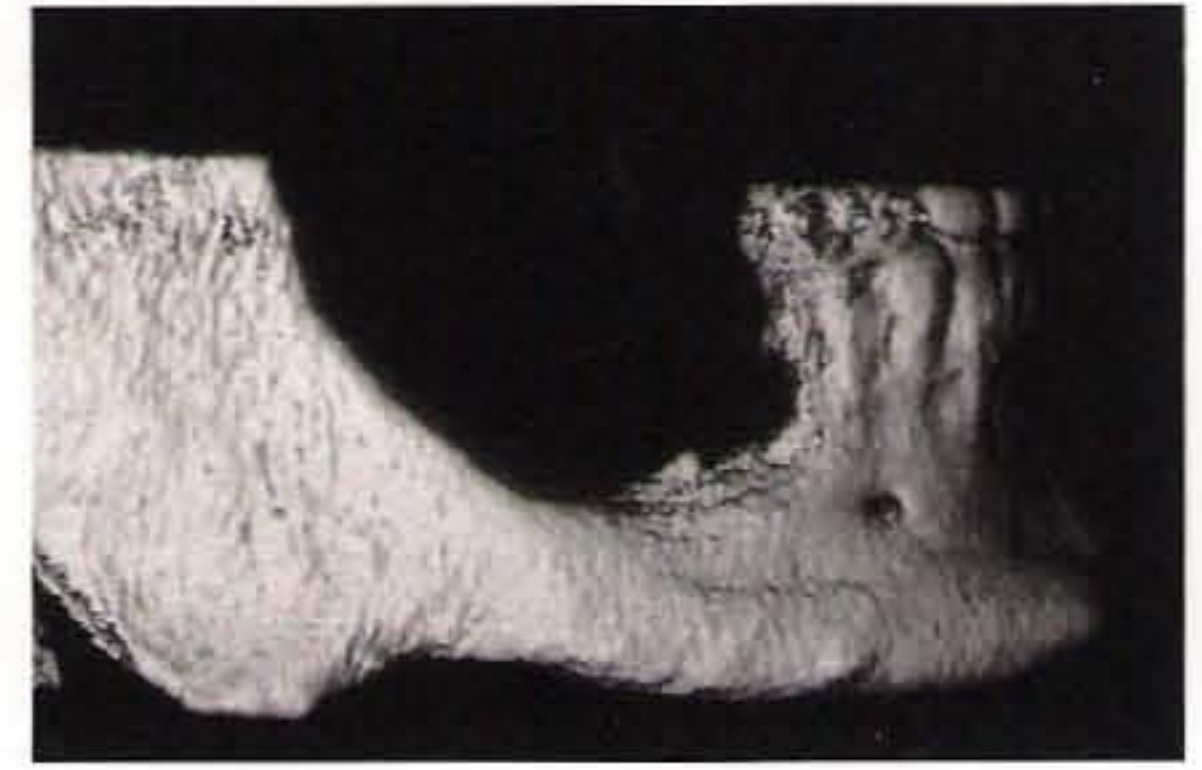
Initial three-dimensional CT scan.
